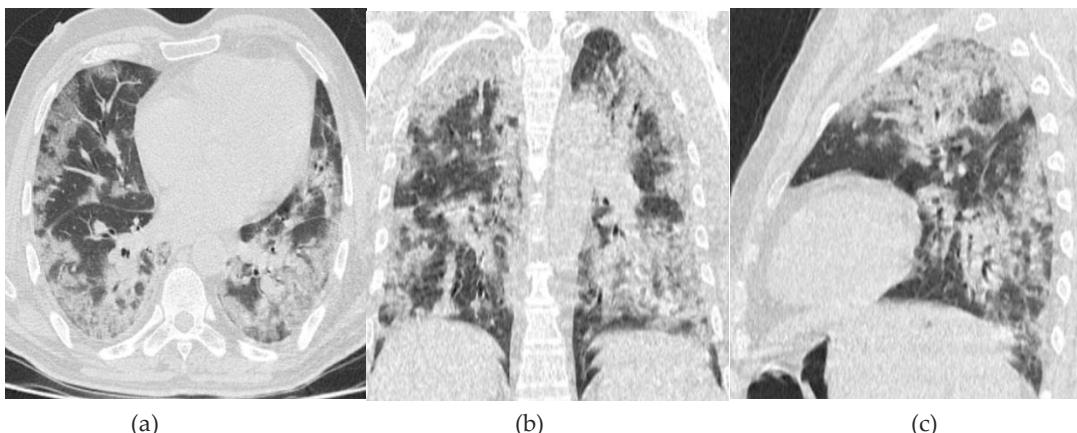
Axial (a) thin-section of HRCT chest scan shows multiple pleural based peripheral areas of ground glass opacities involving bilateral lower lobes. Coronal (b) thin-section shows the severe involvement of bilateral upper and lower lobes with diffuse crazy paving and few peripheral areas of consolidation. Sagittal (c) thin-section shows involvement of left upper and lower lobe, suggestive of severe disease.
